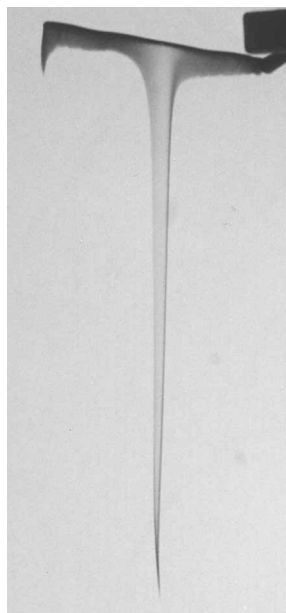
Picture of a stream produced in water in the field of a 3.5 MHz transducer operating in pulsed Doppler mode. (Reproduced from [Starritt \*et al.\*, 1991](#), with permission).
